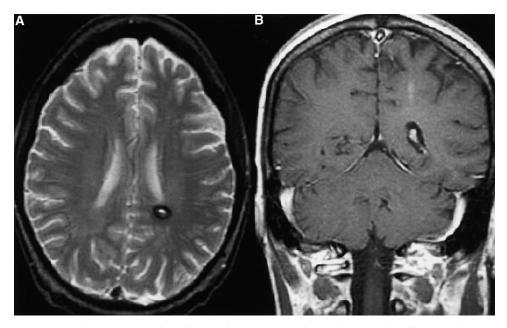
Cavernous angioma. (A) T2-weighted image of a cavernous angioma with a dark rim of hemosiderin surrounding a region of increased intensity. (B) T1-weighted image with contrast demonstrating modest enhancement of the angioma.
